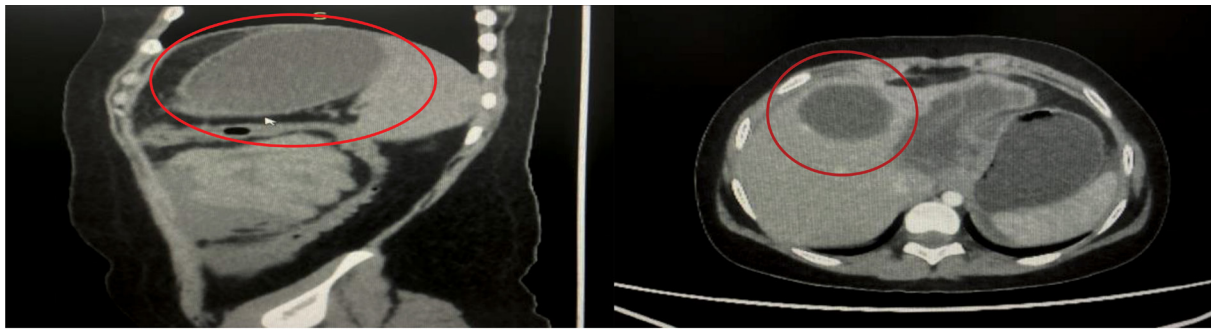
CT imaging - cystic echinococcosis
